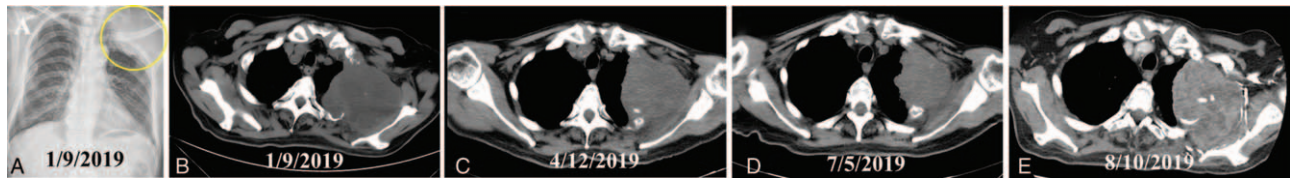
Radiological images of the pulmonary sarcomatoid carcinoma (indicated by arrow) before and after treatment in case 1. A. The X-ray showed a bulky mass located in left upper thorax on admission. B. Further computed tomography revealed the pulmonary tumor invading adjacent ribs. C. The tumor showed PR after 3 months of treatment. D. The tumor was shorter partial remission after 6 months of treatment. E. The lesion was significantly enlarged on the 7-month follow up. CT=computed tomography, PR=partial remission.
